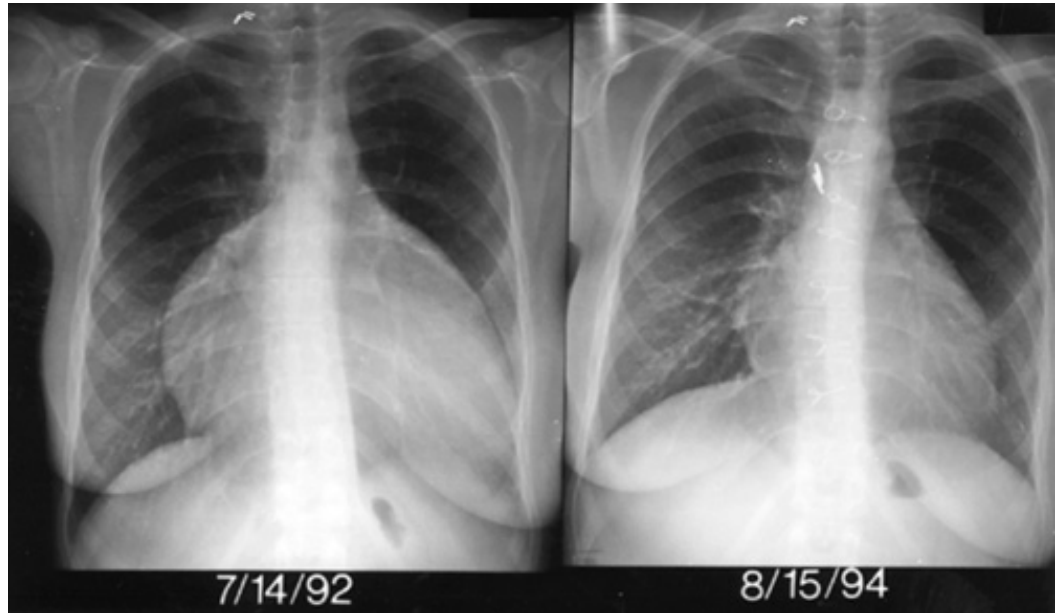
(*Left*). The chest radiograph shows severe cardiac enlargement associated with Ebstein's anomaly in a 32-year-old woman. She had had a right Blalock-Taussig shunt at age 12. (*Right*). Following tricuspid valve repair and closure of a secundum atrial septal defect, there has been dramatic reduction in the size of the heart.
